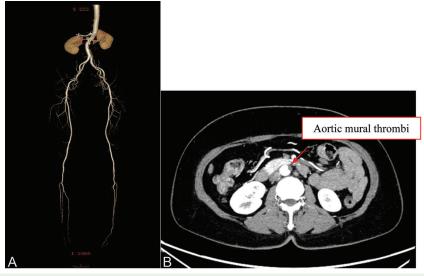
Computed tomography angiography (CTA) on day 14 after anticoagulant administration showed (A) complete recanalization of the anterior tibial artery, posterior tibial artery, and peroneal artery on three-dimensional reconstruction, with (B) a decrease in the size of the concentric intraluminal thrombus of the infrarenal abdominal aorta in the axial view.
